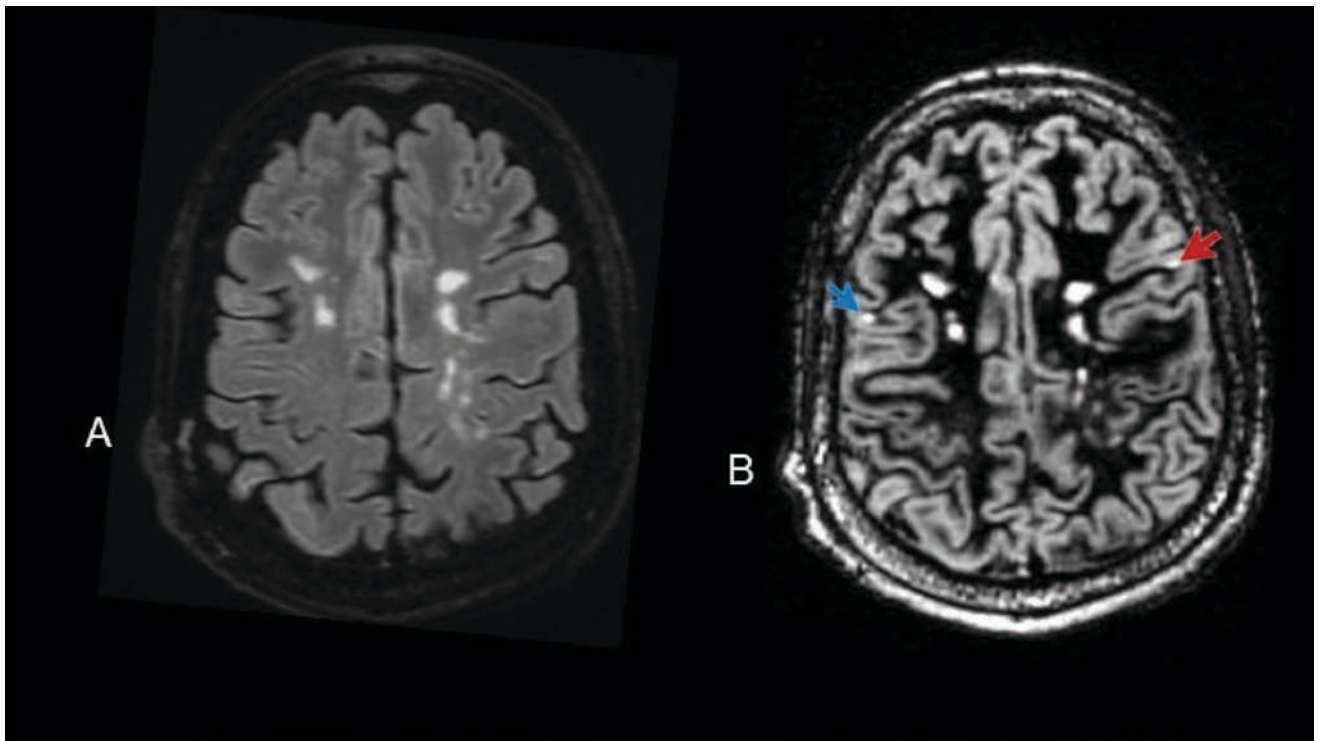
A female patient, age 29, has an EDSS score of 3 and RRMS. At the same level, A. Axial FLAIR and B. Axial DIR showed in contrast to the FLAIR Sequence, the DIR sequences clearly showed the right middle cerebellar peduncle plaque (white arrow), with few cortical, infratentorial involved lesions. Cortical type I (blue arrow) and cortical type II (red arrow) were not present in the FALIR sequence, while be indicated in the axial DIR. C. Sagittal FLAIR. D. Sagittal DIR at the same altitude demonstrated Axial DIR revealed two cortical types that were not discovered in the FALIR sequence: cortical type I (indicated by blue arrow) and cortical type II (indicated by red arrow)
